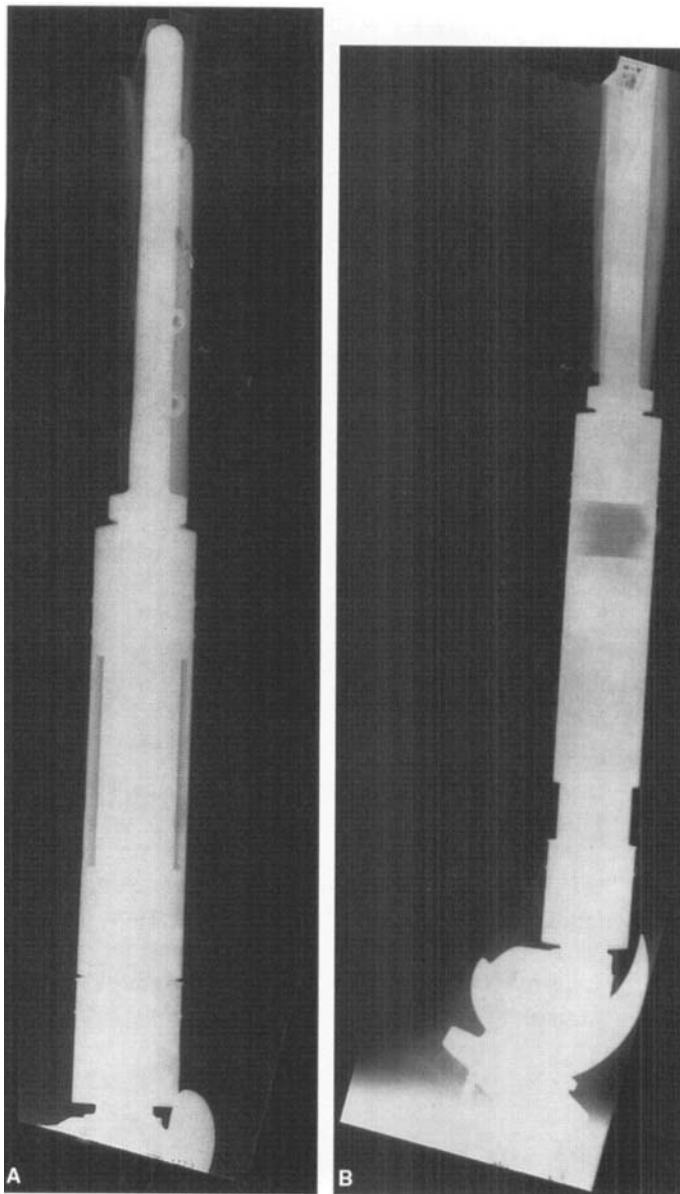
X-rays demonstrating the growth of the endoprosthesis before the extensions (a) and after (b) are shown.
